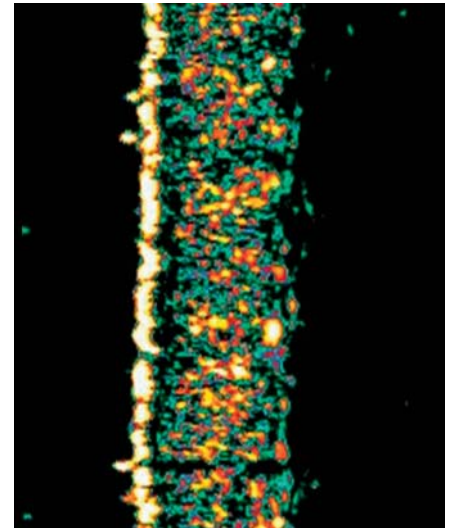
Preflight skin physiological measurements: ultrasound images, L -120 days.
